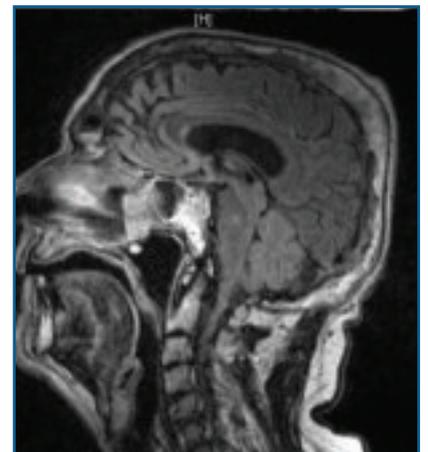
Skull MRI showing thickened skull secondary to Paget's.
